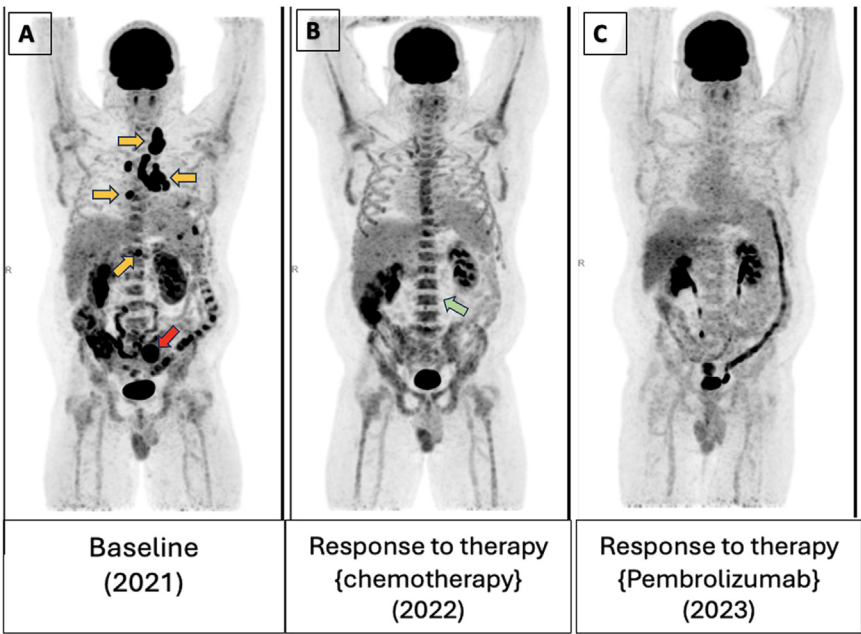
47-year-old male with PD-L1 positive NSCLC. Comparison of [¹⁸F]FDG PET MIP images at Baseline (A), end-of-chemotherapy (B), and on immunotherapy (C). Baseline MIP image shows neoplastic adenopathy in the neck, thorax and abdomen (orange arrows), and skeletal metastases in left sacrum (red arrow) on baseline images. He completed six cycles of chemotherapy. Three weeks later, a PET/CT scan was done to evaluate response to chemotherapy which showed no evidence of metabolic activity in previously identified lesions, indicating complete metabolic response to therapy. Diffuse uptake noted in the spine was attributable to bone marrow response to recent chemotherapy (green arrow). Patient received anti PD-1 therapy (Pembrolizumab) and on follow-up imaging, MIP image (C) showed no evidence of active disease on immunotherapy.
